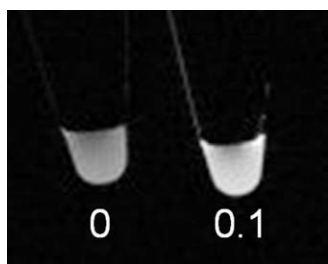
MR images at 4.7 T of hydrogels containing 0 mM Gd(III) and 0.1 mM Gd(III) of the K8-120 PPCA. Imaging parameters: TR/TE = 100/14.6 msec, 128×128 matrix, 3 cm FOV, 1 mm slice thickness, and 20 signal averages.
